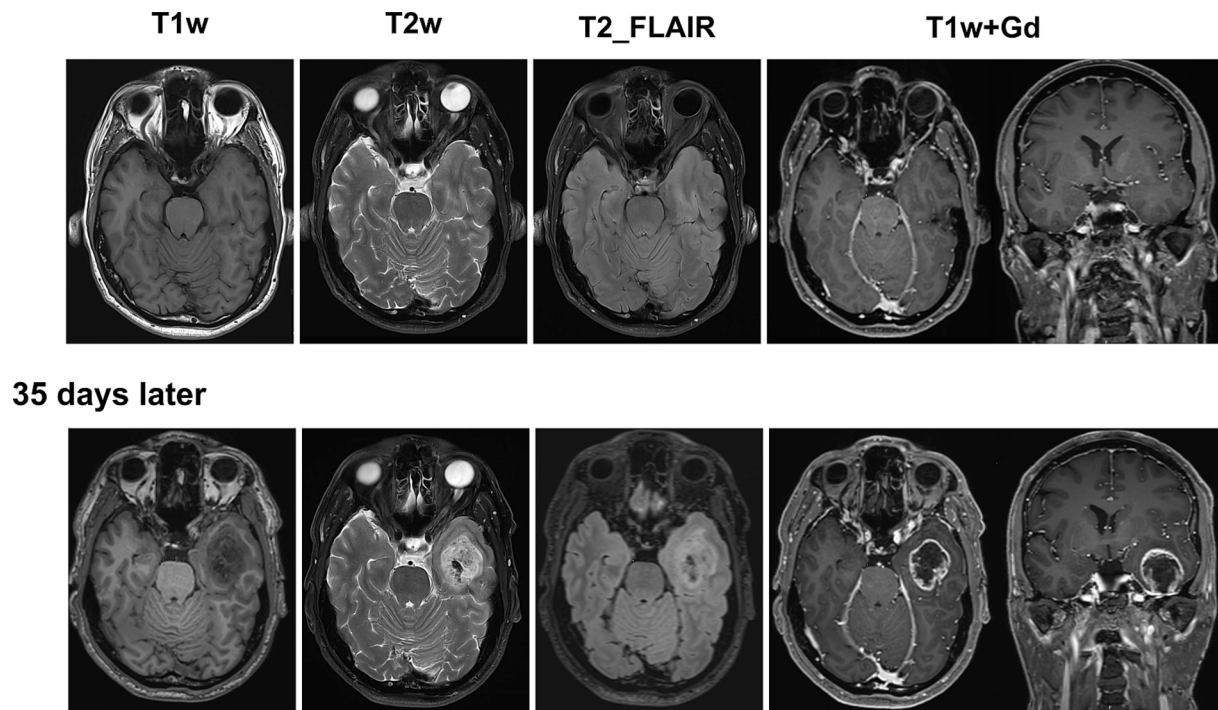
Brain MRI in axial and coronal planes after the first inaugural seizure (top row), considered normal, and five weeks later (bottom row) across the region where the glioblastoma multiforme appeared.
